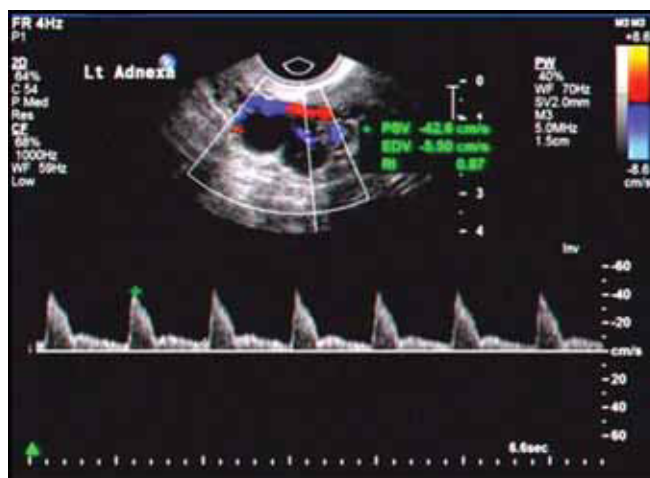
Complex ovarian mass. Doppler ultrasound with high resistance blood flow not suggestive for neovascularization
